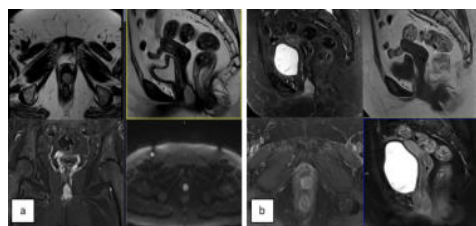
(a&b) CEMRI PELVIS (T1W,T2W,STIR,DWI AND TWI POST CONTRAST) AXIAL, SAGITTAL AND CORONAL image shows a well defined mild heterogeneously enhancing lobulated soft tissue lesion along the lateral wall of lower one third of the vagina with intraluminal extension displaying high signal intensity on long TR
